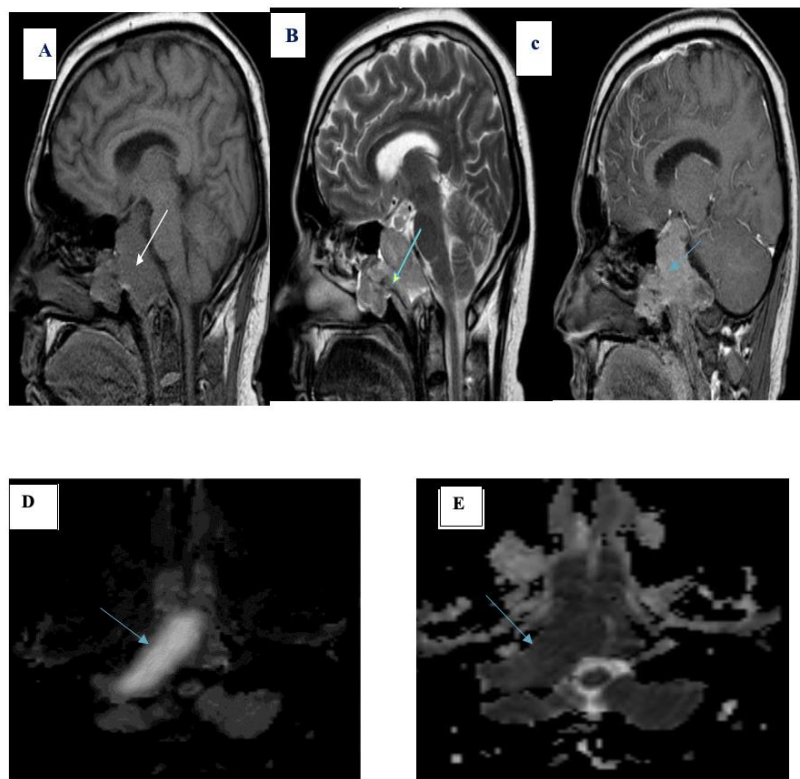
MRI findings in male patient aged 56 presented with vomiting and headache, (A) and (B) Sagittal T1W and T2W cuts show large isointense soft tissue lesion infiltrating the clivus with invading sphenoid sinus, nasopharynx cavity and Rt cerebellopontine angle region (arrows), (C) contrast-enhanced sagittal cut shows mild homogenous enhancement (D) and (E) DWI and ADC map images show restricted diffusion and a high ADC -value ($1.75 \times 10^{-3} \text{ mm}^2 / \text{S}$), pathologically proved clivus chordoma
